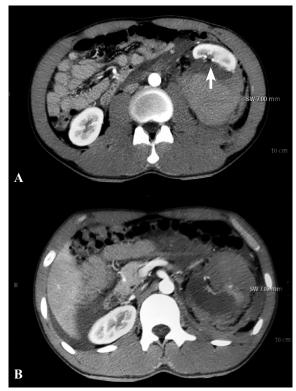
CT scan abdomen with contrast was immediately conducted after trauma occurred. A, The figure shows grade IV renal traumatic injury (arrow). B, The contrast enhanced in nephrographic phase, showing laceration in the lower extremity of the left renal. Meanwhile, wide perirenal hematoma is still stuck by renal capsule.
